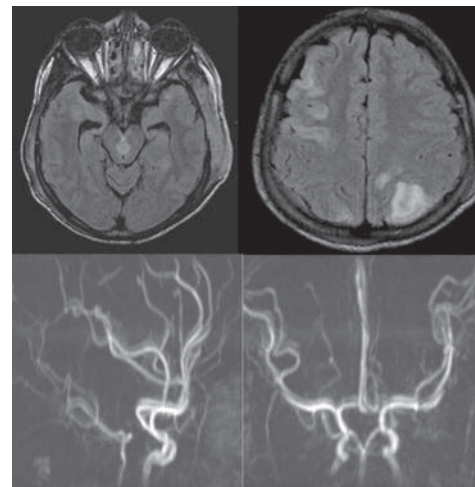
MRI brain (FLAIR) images reveal hyperintense signal changes in the periaqueductal grey matter and right frontal and left parietal regions. MR angiography did not reveal any abnormality.
